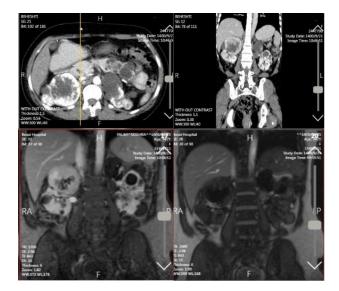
Abdominopelvic CT scan with IV contrast showing multiple cyst in both kidneys. Note right kidney upper lobe necrotic mass and left kidney Bosniak class 4 mass. T1-weighting hypointense and T2-weighting mix signals of right kidney mass. Multiple cysts in both kidneys and pancreas.
